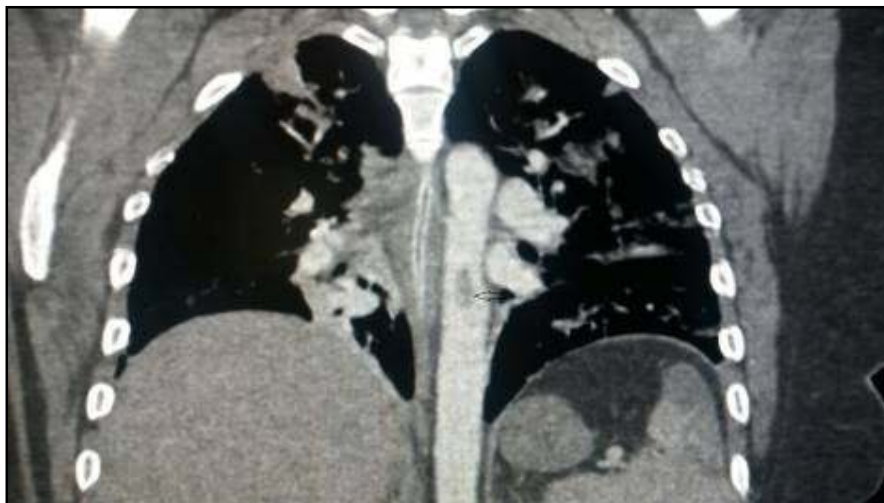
Thoracic-Abdominal CT angiography showing partial occlusion of the III medium of the thoracic aorta (a 15 mm fluctuating thrombus formation occluding 60% of endovascular space)
